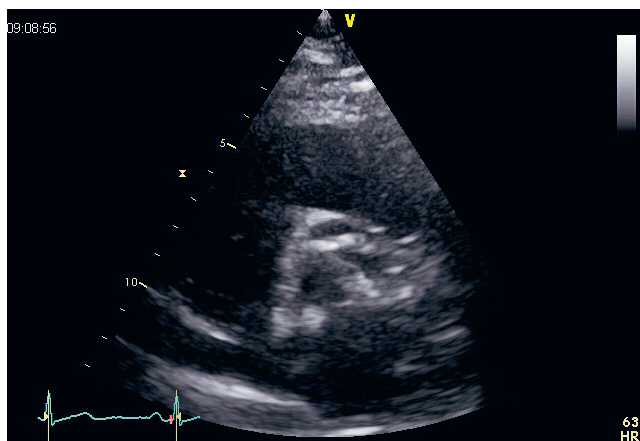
Image of SAS in short axis parasternal transthoracic view
